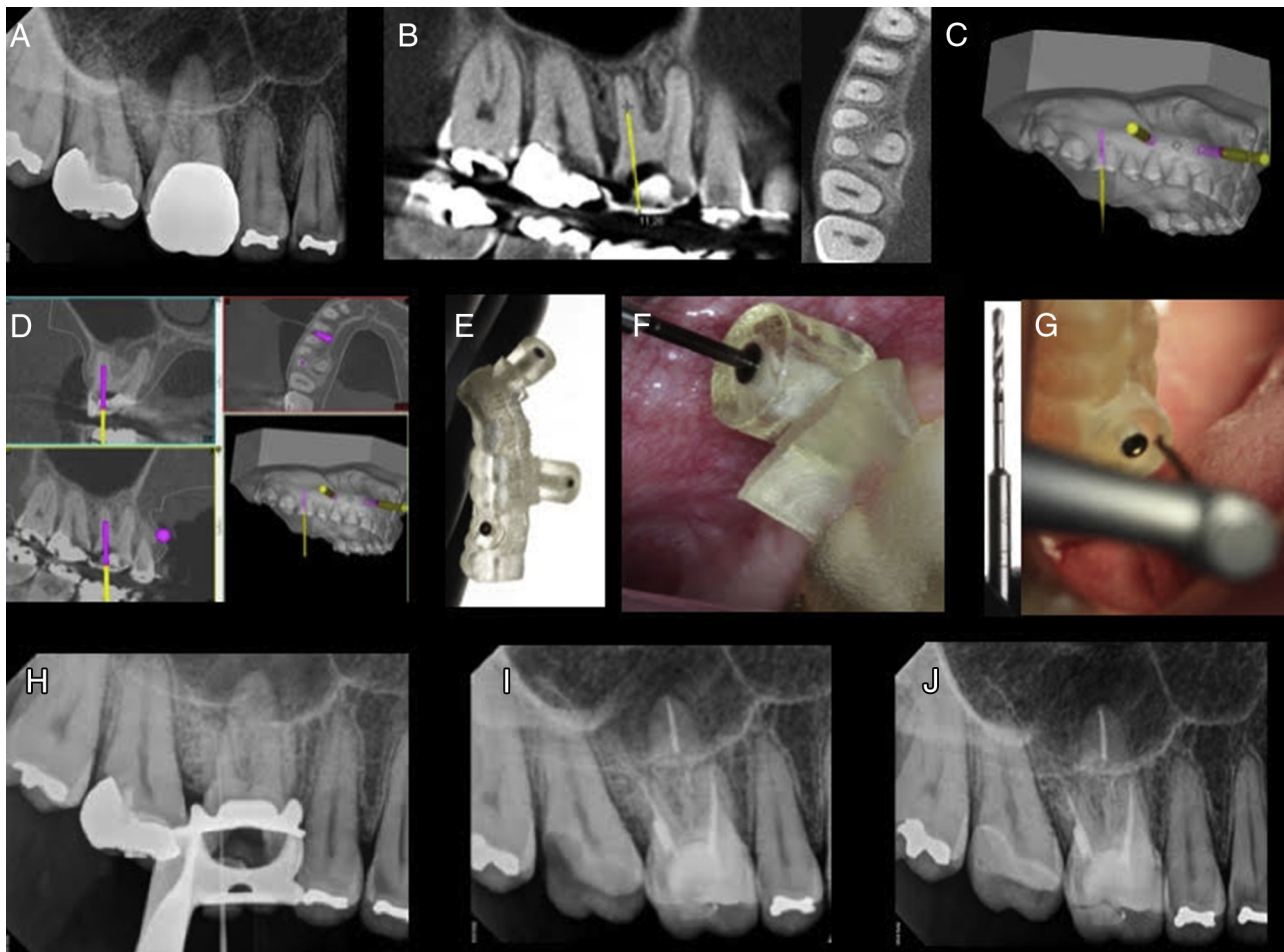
(A) Radiographic examination of the second upper premolar. (B) A CBCT image showing partial obliteration of the root canal and apical periodontitis. (C) A 3D model of the oral cavity. (D) 3D root canal planning. (E) Perforations performed for guide fixation. (F) The bur positioned in the 3D template. (G) Canal patency. (H) The final radiograph. (I) The radiograph at the 6-month follow-up. (J) The radiograph at the 1-year follow-up.
